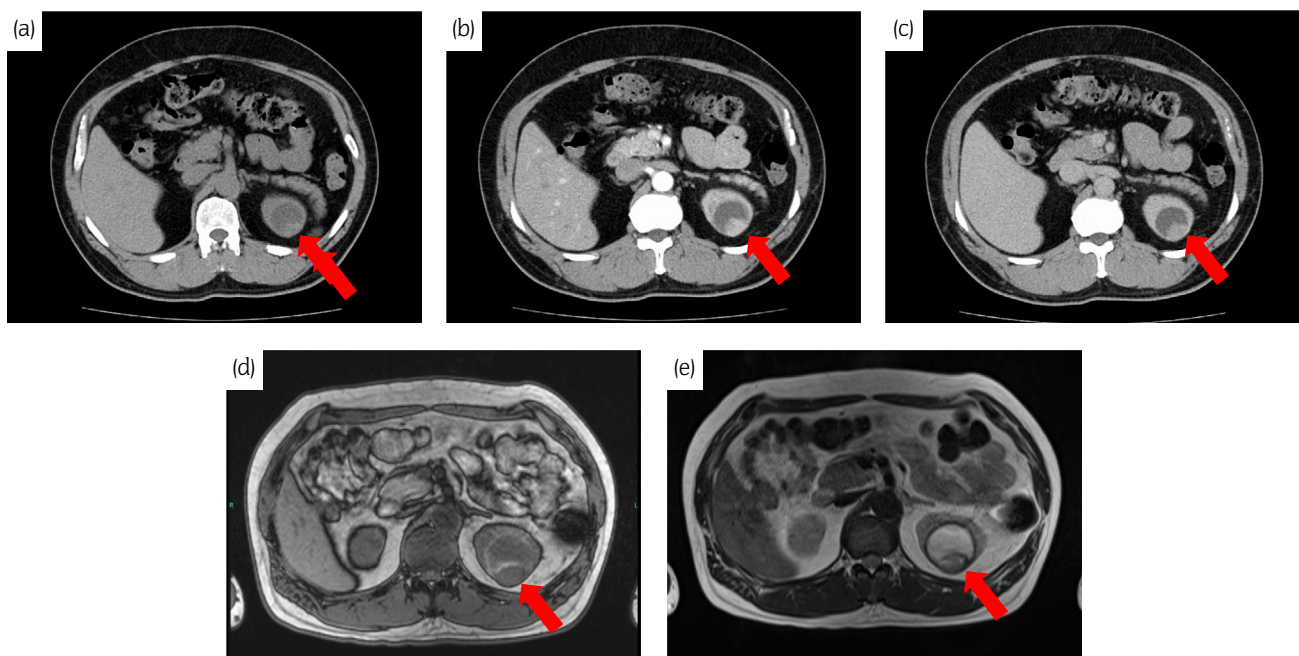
Plain CT showed a cystic mass measuring 43 mm in diameter at the upper pole of the left kidney, with a 20-mm parenchymal component inside the cyst. Enhanced CT showed strong contrast effect on the tumor at the early phase, with disappearance of this effect at the late phase, suggestive of clear-cell RCC with a cystic component. With MRI, the tumor showed low intensity on the T1-weighted image and high intensity on the T2-weighted image. The red arrow indicates renal tumor. (a) Plain CT. (b) Early-phase enhanced CT. (c) Late-phase enhanced CT. (d) T1-weighted MRI. (e) T2-weighted MRI.
